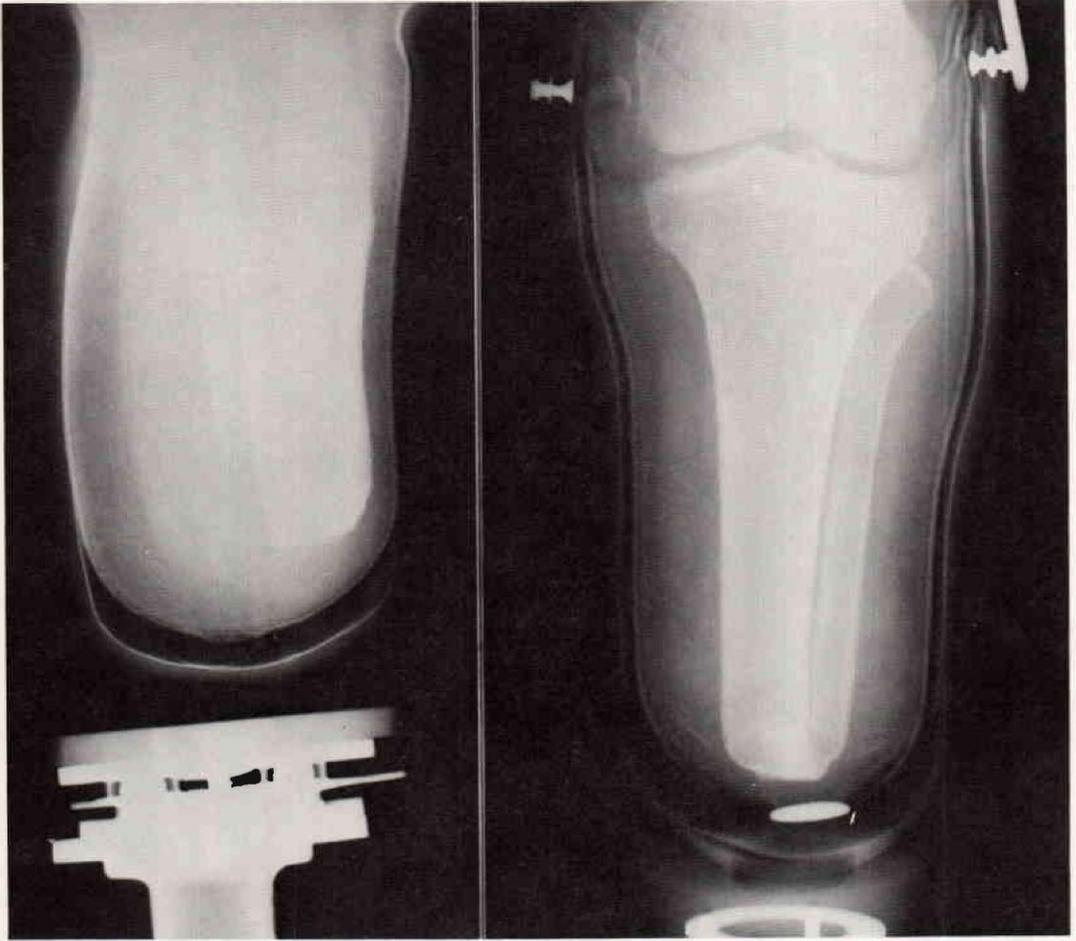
X-ray views of patient in the prosthesis. On the right a coin has been placed on the distal end of the stump for reference.
